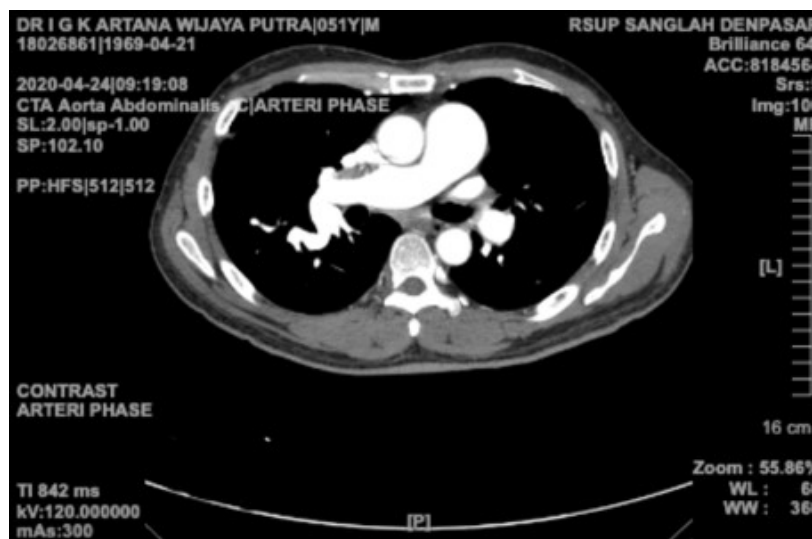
Right Pulmonary Artery Dilatation on Pulmonary CT Angiography
